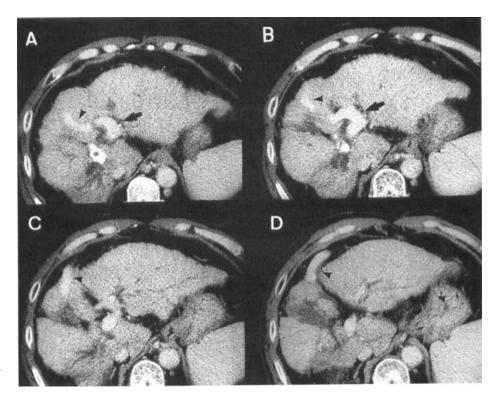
Contrast-enhanced computed tomography (CT) findings of case 1. (a,b) Single collateral vein (arrowhead) originating from the left portal vein (arrow) passes through the medial segment of the liver and (c,d) reaches to the hepatic surface without passing through the fissure of ligamentum.
